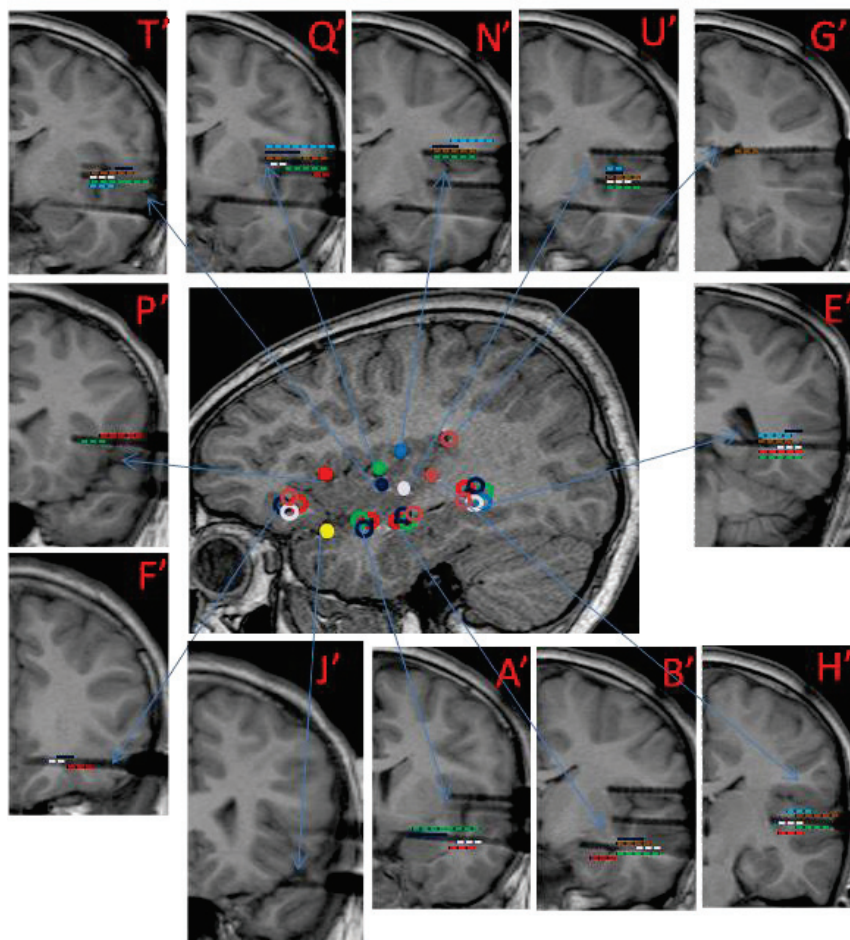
4: Patient 4 MRI with electrodes in place (Left hemisphere). Central sagittal image: each insular electrode is represented by a unique colored solid circle; non-insular electrodes are represented by empty circles with the color of each of the insular electrode they are responding to. Yellow solid circles are for non responding electrodes. Peripheral coronal images: a cross-section of each electrode with its name and its responding contacts (responses are indicated by color coded dotted lines, representing the color of the corresponding stimulated insular electrode).
